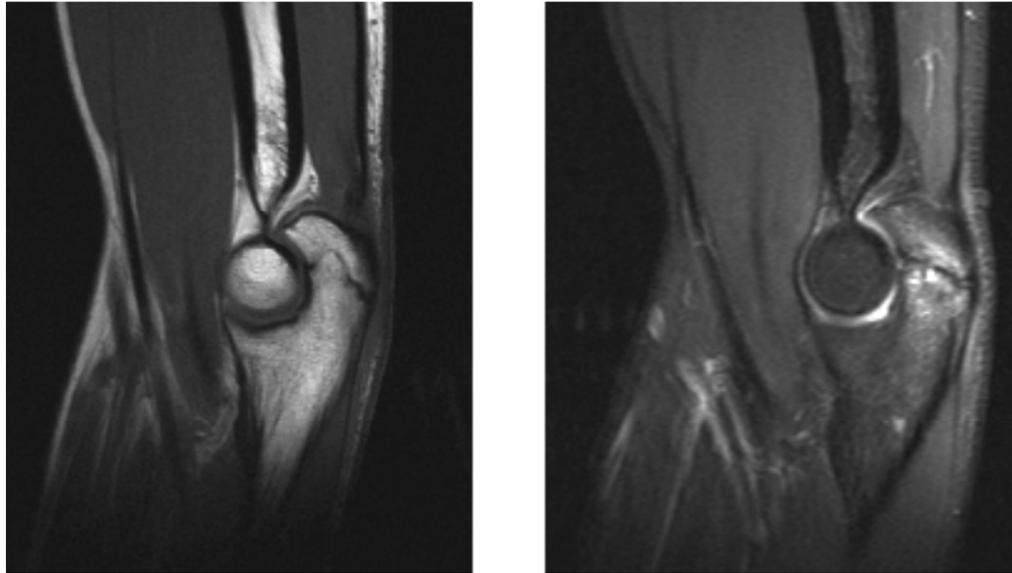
(a,b): MRI (T1 and Tirm sequence) of the right elbow showing a widening of the epiphyseal plate of the olecranon and associated adjacent bone marrow oedema.
